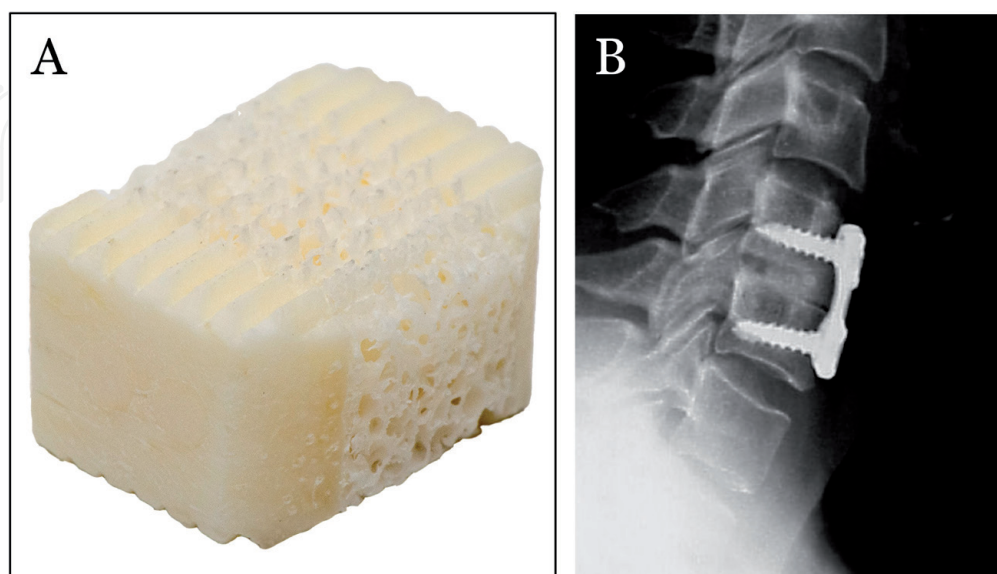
(A) Structural interbody spacer with cancellous bone sandwiched between two plates of cortical bone. (B) Lateral X-ray 6 months after ACDF was performed in a 47-year old woman from C4-C5 using the structural interbody spacer shown. Complete fusion and good alignment were achieved. Modified and reprinted with permission from Abla et al. [48].
